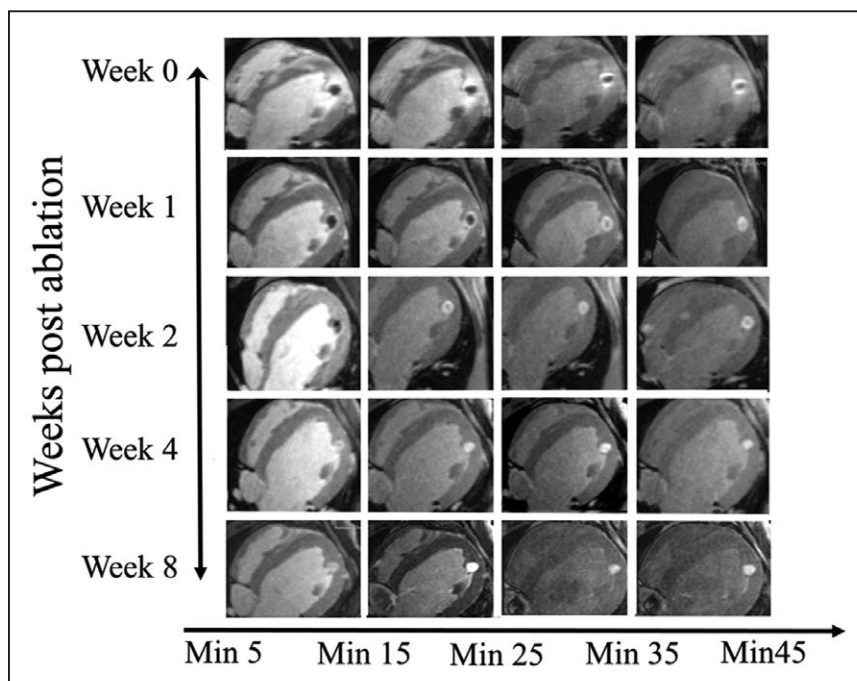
An example of the appearance of a lesion on the late gadolinium enhancement magnetic resonance imaging at different time points (wk 0, 1, 2, 4, and 8) and with different delays between contrast injection and image acquisition.
